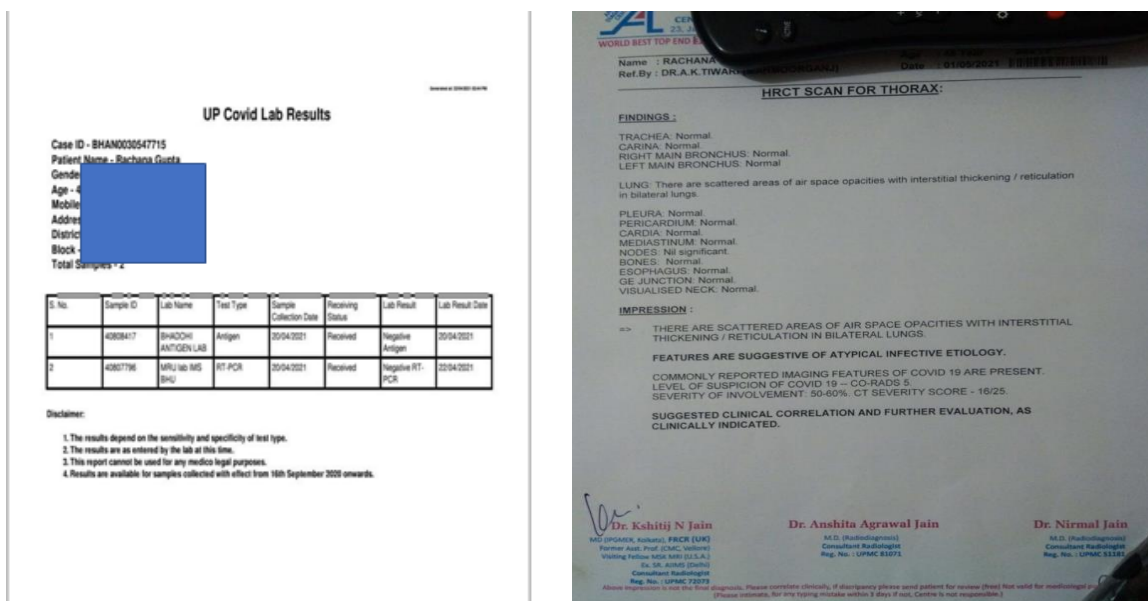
Before treatment RT-PCR (20/4/2021), HRCT THORAX (1/05/2021).
